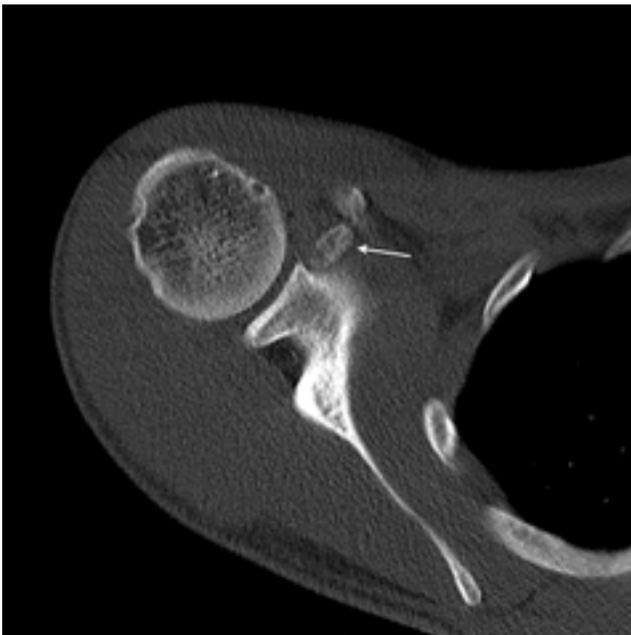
Patient KW, age 19. Axial computed tomography cross-section. Free bone fragment of the caracoid process of the scapula (arrow).
